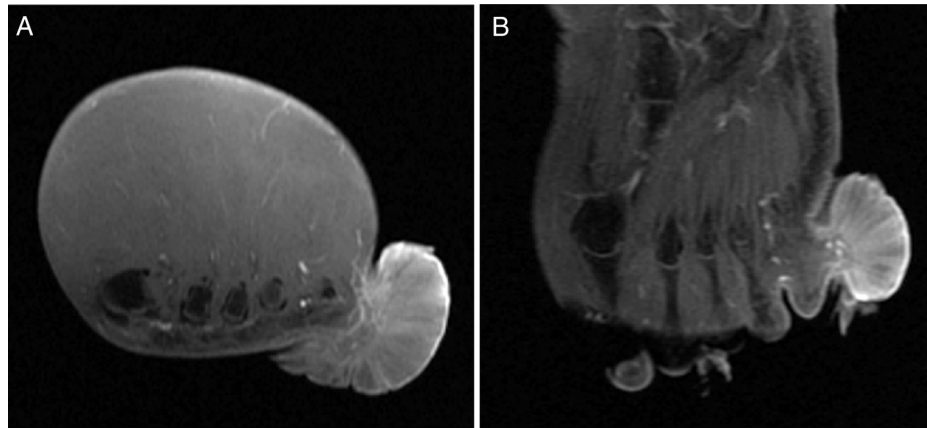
(A) Axial and (B) coronal views of T₁-weighted contrast-enhanced magnetic resonance imaging scan of the left foot showing an enhancing, exophytic, fungating, multilobulated mass measuring 3.1 cm in depth and 4.7 × 5.9 cm across. The mass was connected to the toe by a thick stalk but was distinct from the normal-appearing bones of the underlying fifth toe.
